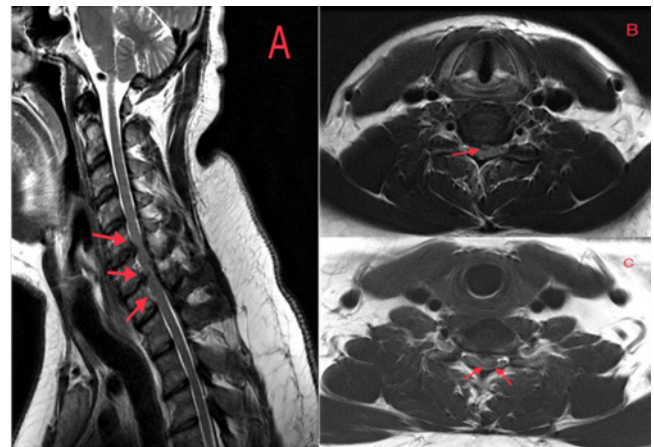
Figure A: T2-weighted sagittal magnetic resonance image. A C5-6 herniated disc is seen indenting the cord. C6-C7 large migratory disc reaching upperhalf of C7 vertebra and causing marked spinal cord stenosis; Figure B: T2-weighted axial magnetic resonance image, A C5-C6 hemiated disc is seen indenting the spinal cord slightly to the Left side; Figure C; T2-weighted axial magnetic resonance image, A C6-C7 large disc hemiation causing marked spinal cord compression
